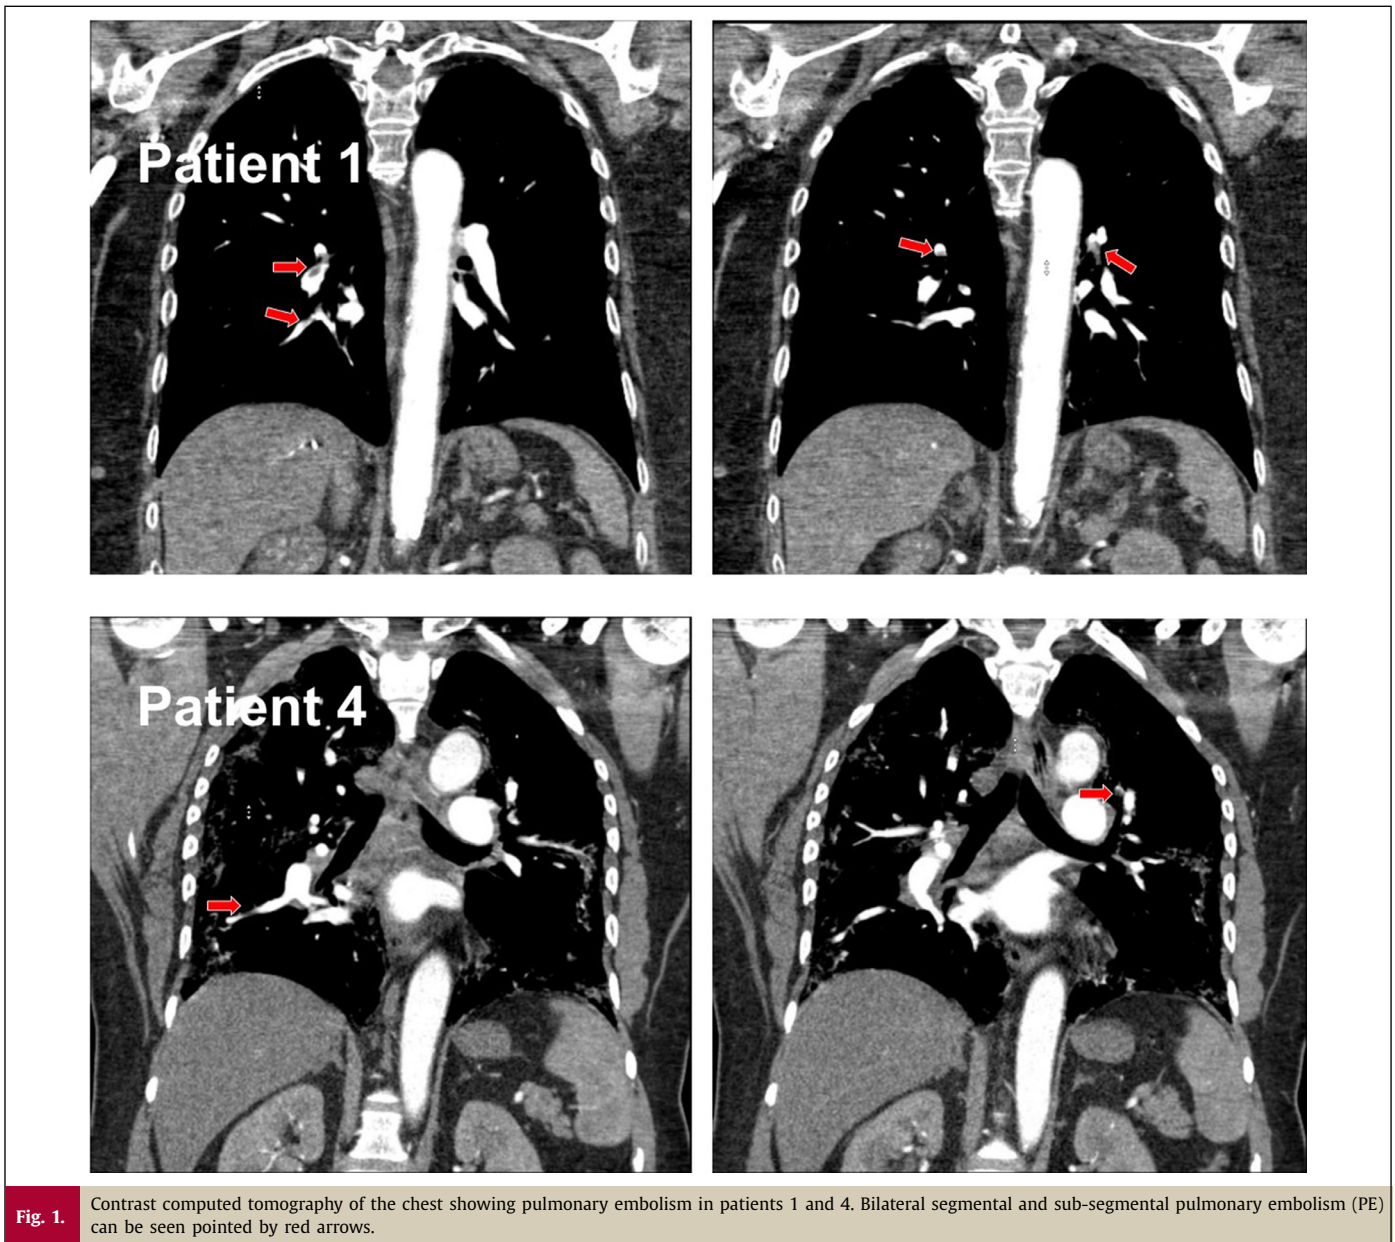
Contrast computed tomography of the chest showing pulmonary embolism in patients 1 and 4. Bilateral segmental and sub-segmental pulmonary embolism (PE) can be seen pointed by red arrows.
